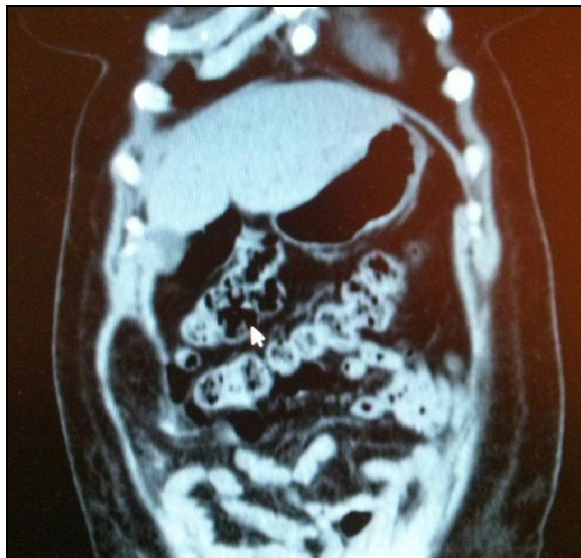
Sagittal CT slice depicting hernia sac
